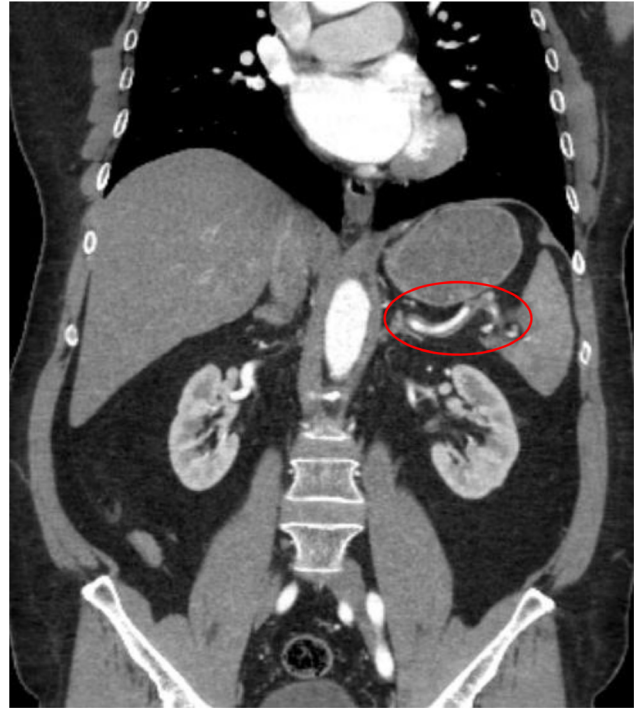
Coronal CTA demonstrating thrombosed false lumen along length of splenic artery and into the splenic hilum.
